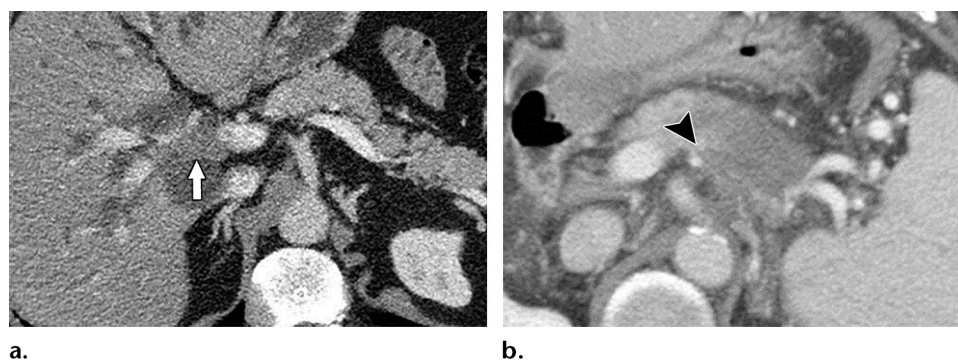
Appreciable vascular involvement in extrahepatic cholangiocarcinoma (a) and pancreatic ductal adenocarcinoma (b). (a) Axial contrast-enhanced CT image of a 77-year-old man shows right portal vein encasement and narrowing by the hilar mass (arrow). (b) Axial contrast-enhanced CT image of a 65-year-old man depicts thrombosis of the splenic vein and artery secondary to encasement by the adjacent pancreatic adenocarcinoma (arrowhead).
